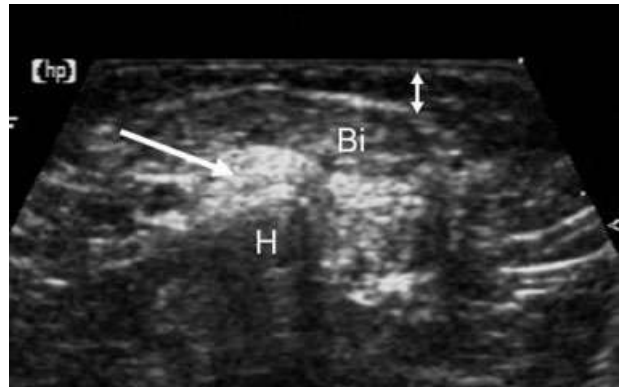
Transverse ultrasound scan of the upper arm of a 1-year-old child with nemaline myopathy. The muscle echo intensity is slightly increased in the biceps brachii muscle (Bi). The brachialis muscle, however, shows a very high echo intensity (arrow). H, humerus; double arrow, subcutaneous tissue.
